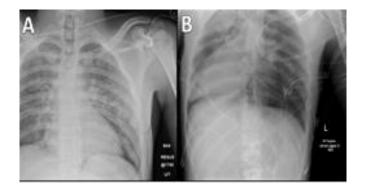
Chest X-ray on admission (A) and 7 hours later in intensive care (B)
